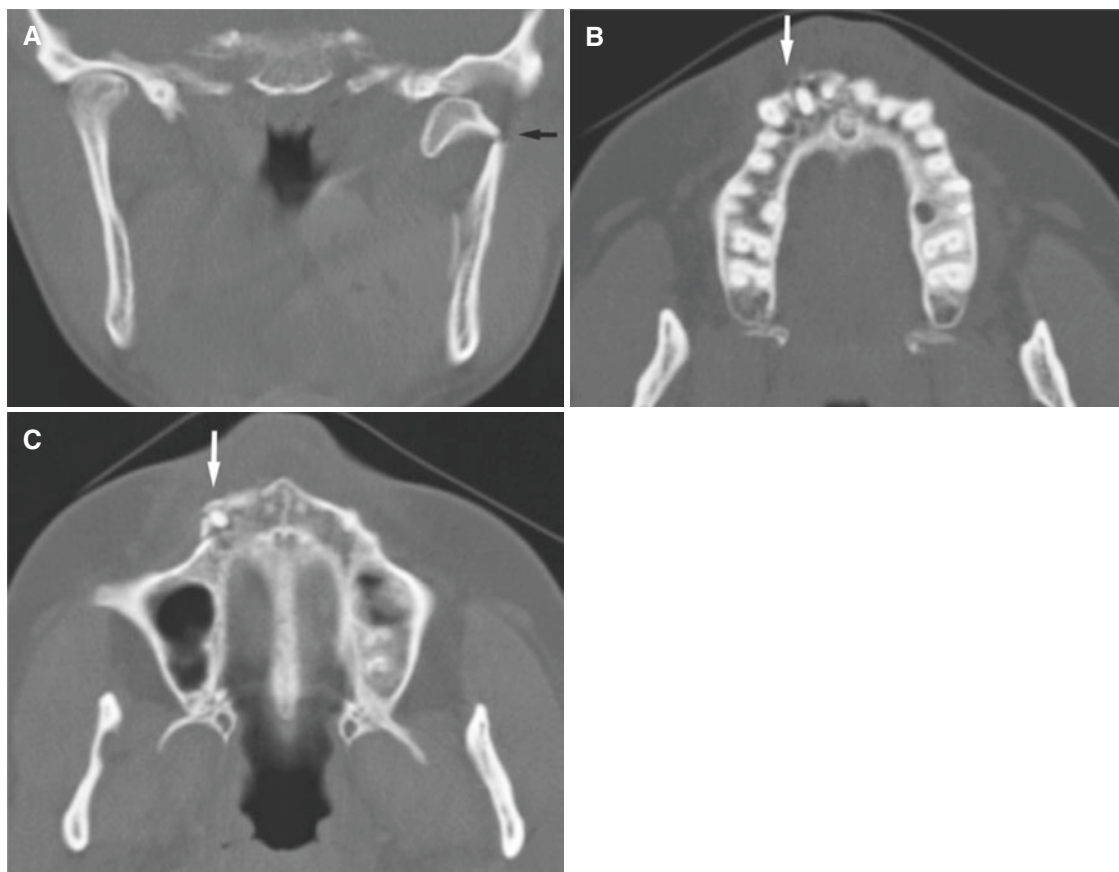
Mandibular neck and maxillary alveolar process fractures; 33-year-old female with trauma to the chin and maxilla. (A) Coronal CT image shows fracture of the left mandibular neck (*arrow*). (B) Axial
